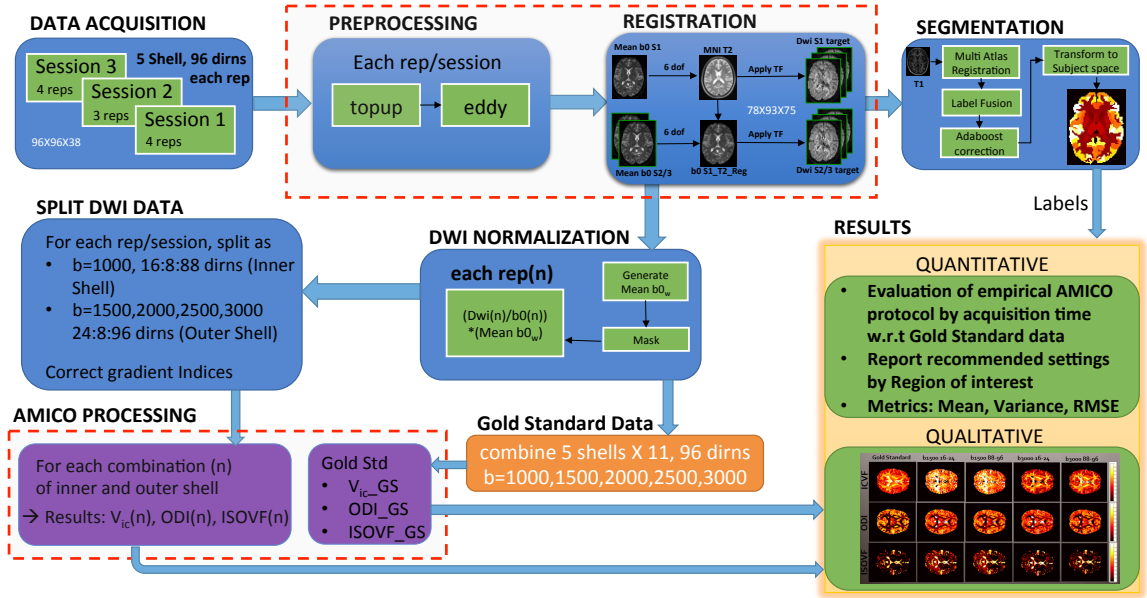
1 Data acquisition included 3 sessions of 5 shells with b values of 1000, 1500, 2000, 2500 and 3000s/mm² each with 96 gradient directions and a total of 11 repeats. Preprocessing included topup and eddy current correction after which all the images are registered to MNI template. Mean b₀ is generated from these images and DWI normalization is performed. For each repetition and session, normalized DWI data is then split into n multiple combinations including inner and outer shells based on corrected gradient indices to account for uniform sampling. AMICO processing is performed on each of these combinations thus yielding metrics V_{ic}(n), ODI(n) and ISOVF(n) for each combination. Data from all shells and repeats are combined to obtain full protocol that is considered to be the gold standard dataset. with V_{ic}_GS, ODI_GS and ISOVF_GS as corresponding metrics from AMICO processing. Multi atlas label segmentation is performed on the T1 image and labels are obtained through label fusion method, which is used in further quantitative analysis. Results included both qualitative and quantitative metrics.
